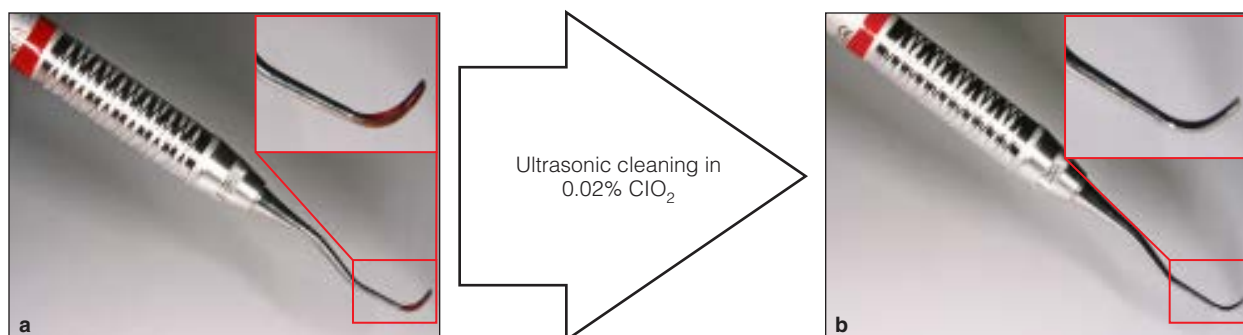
Effects of ultrasonic cleaning with ClO_2 on the removal of HCV from HCV-infected patient-derived dental instruments. After subgingival scaling on molars, (a) blood and saliva adhered to the surface of a periodontal curette and (b) were visually removed by ultrasonic cleaning in 0.02% ClO_2 . (c) Real-time PCR detected HCV RNA in instruments that had been used in four HCV-infected patients (2.0–4.6 log IU/mL). In contrast, HCV RNA was not detected in the instruments after ultrasonic cleaning in 0.02% ClO_2 .
